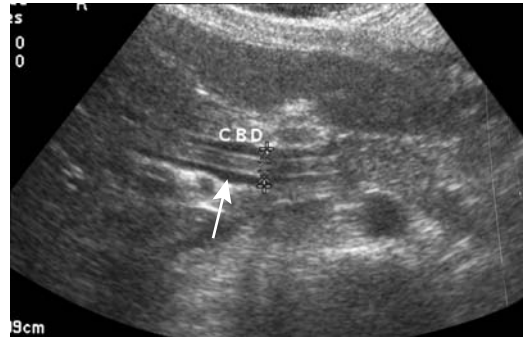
Biliary ascariasis. Ultrasonography shows a tubular hyperechoic structure (arrow) in the common bile duct. (Courtesy of Ronald O. Bude, M.D., University of Michigan.)
